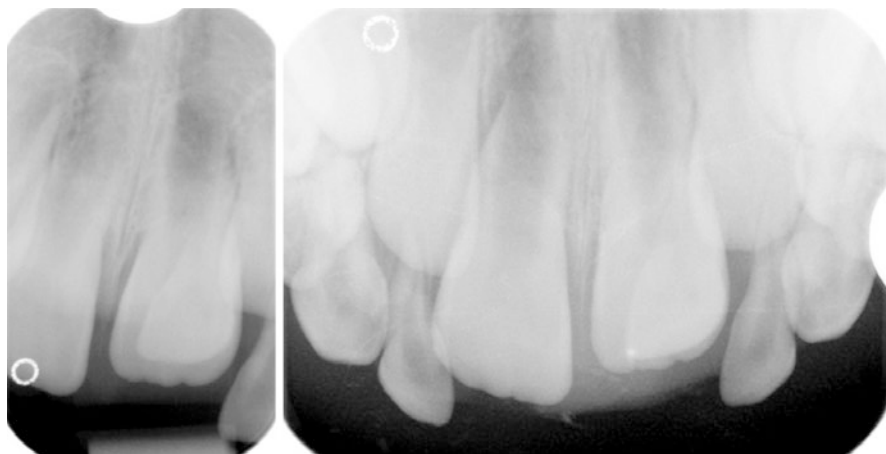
This is a case of intrusion of the left-hand-side maxillary primary central incisor. Both radiographs were taken using the occlusal technique at a 65° angle of the X-ray beam to the occlusal plane, while the photostimulable phosphor plate was on the occlusal surface. The child was sitting on the mother's lap, who was wearing a lead-equivalent apron. The mother was also holding a thyroid shield under the child's chin to protect the thyroid gland from being irradiated by the primary radiation beam. The intruded primary incisor was removed under local anesthesia, as the eruption of the permanent teeth was eminent
